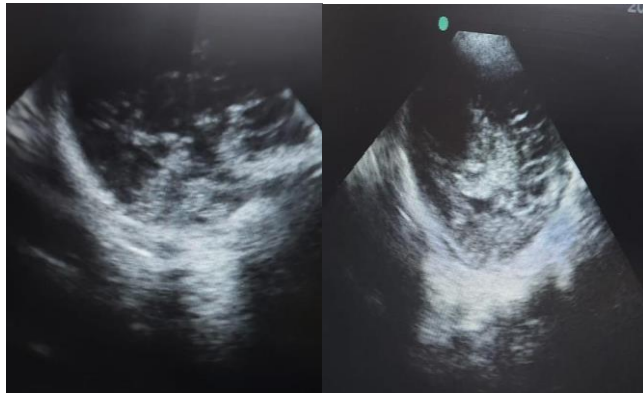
Ultrasound examination of the head
